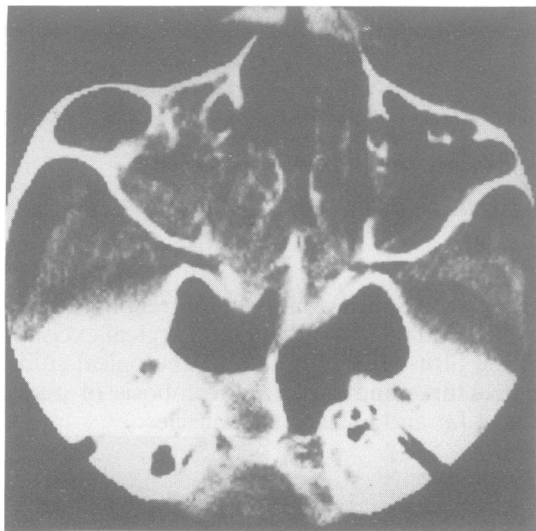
Enhanced CT scan showing soft tissue within the left antrum, erosion of the medial border of the antrum and soft tissue extending medially into the nasal cavity.
